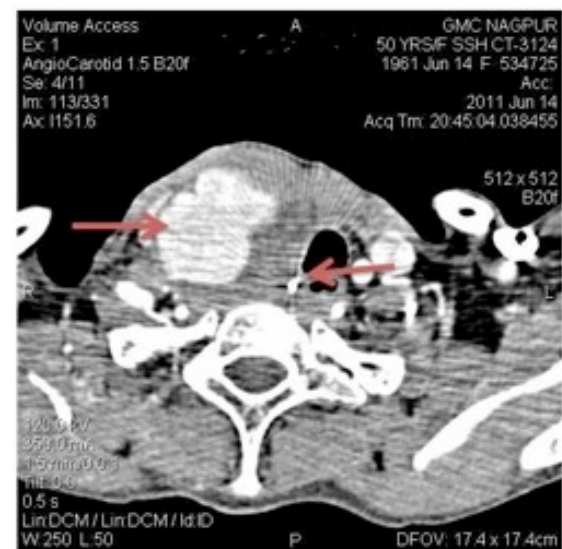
Axial section through neck, CT Angiography showing large pseudoaneurysm involving the proximal right CCA. The pseudoaneurysm displaces the trachea towards the left. The right internal jugular vein was compressed. Arrows showing foreign body.
